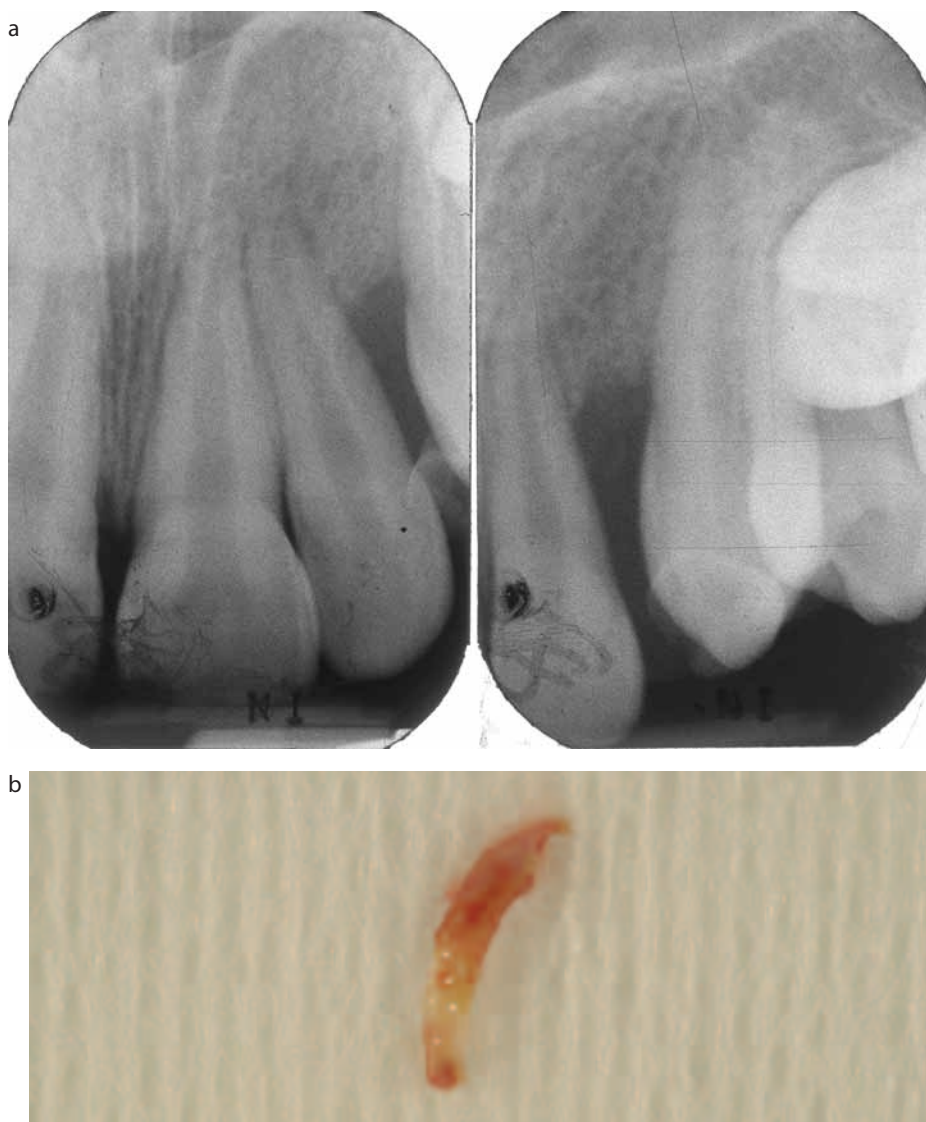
(a) Periapical radiographs of UL123 taken at initial examination pre-treatment. (b) Fragment of finger nail following removal.
